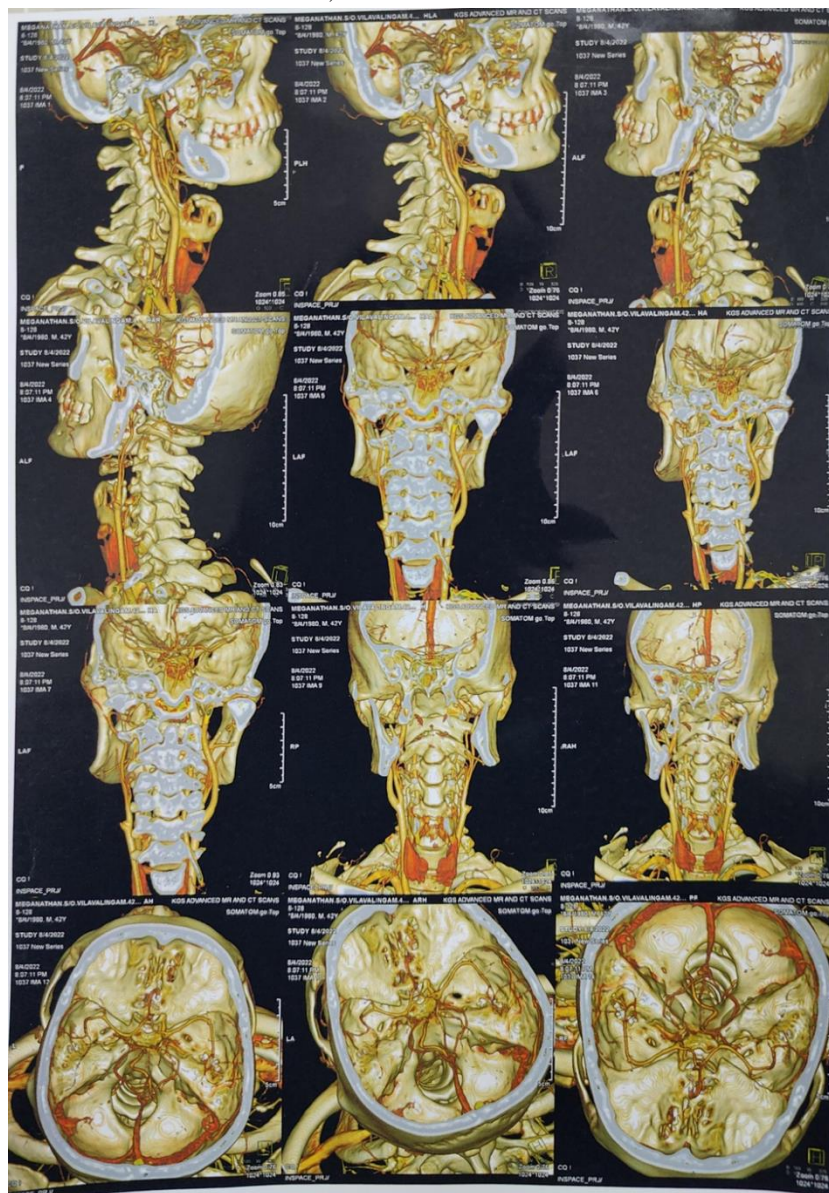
MRI Brain with MRA 3D Reconstruction
